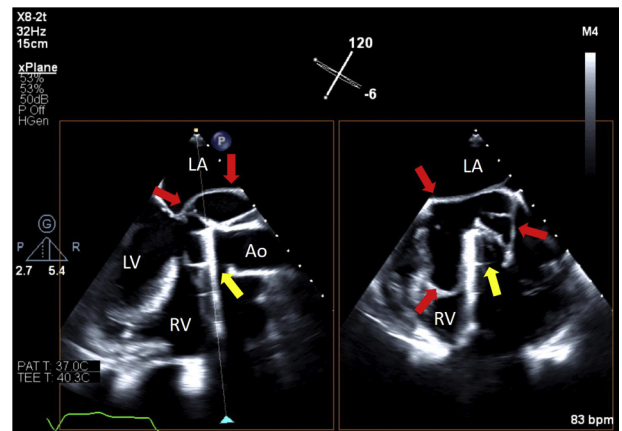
Transesophageal imaging from the midesophageal position, using x-plane to show the pseudoaneurysm in the long-axis (left) and short-axis (right) views. The extent of the pseudoaneurysm is demonstrated (red arrows) surrounding the prosthetic aortic valve (yellow arrows). Ao, Aorta; LA, left atrium; LV, Left ventricle; RV, right ventricle.
